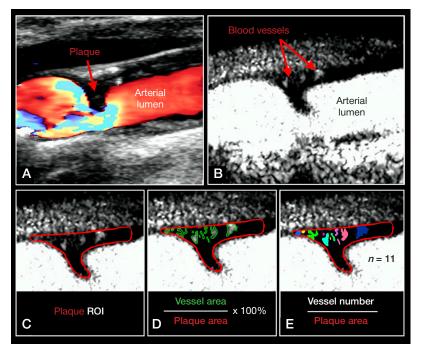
Quantitative methods for the assessment of carotid atherosclerotic plaque neovascularization from contrast-enhanced ultrasonography data. A. A heterogeneous, predominantly hypoechoic atherosclerotic plaque on a conventional Color Doppler Image. B. Contrast-enhanced ultrasonography: a predominantly hypoechoic atherosclerotic plaque with single hyperechoic echogenic components (blood vessels, shown by arrows), hyperechoic arterial lumen and surrounding tissue. C–E. Quantitative analysis of intraplaque neovascularization on a still frame showing the max number of blood vessels (the contour of the plaque is shown in red): ultrasound signal intensity (ROI) (C); the ratio of the total vessel area to the plaque area (blood vessels are shown in green) (D); blood vessel number per 1 cm² of the plaque (blood vessels are shown in different colors) (E)
